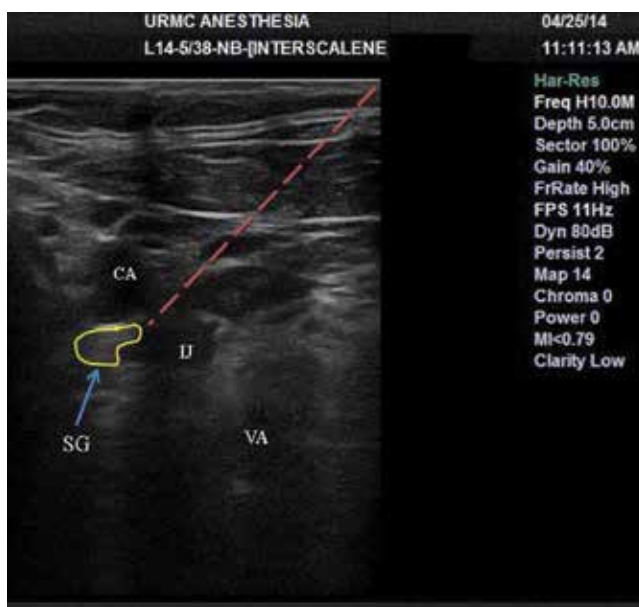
Ultrasound of left stellate ganglion (SG) block using the intervascular approach between carotid area (CA) and internal jugular (IJ) vein is shown. VA is vertebral artery; dashed red line is course of 18 gauge Tuohy needle and subsequent 20 gauge polyethylene catheter [93].
